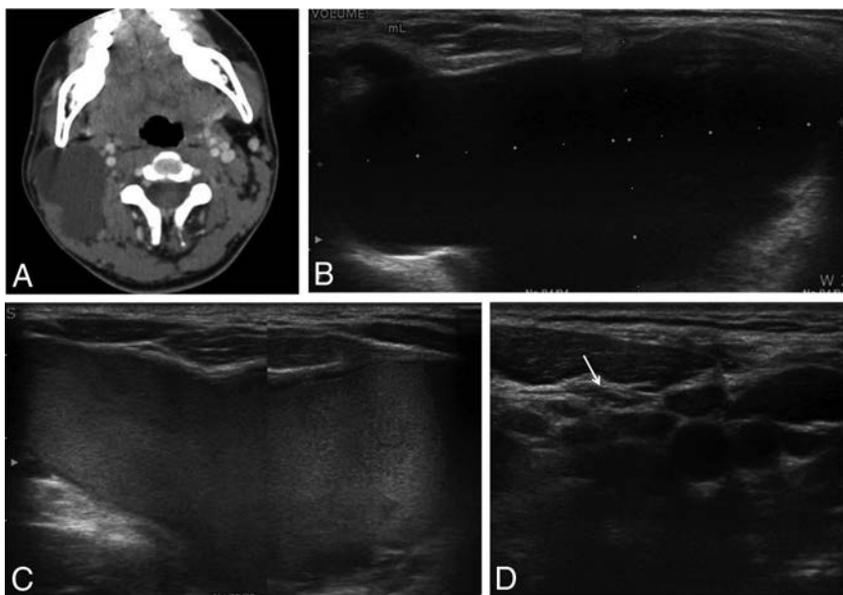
A 15-year-old adolescent boy with a right-neck mass. *A* and *B*, Transverse US and CT scans show a 7-cm cystic mass in the right neck (volume, 36.6 mL). *C*, During the ethanol ablation, intracystic hemorrhage developed after aspiration of internal contents. *D*, However, after a second session of ethanol ablation, the cystic mass had disappeared on follow-up US (*arrow*).
